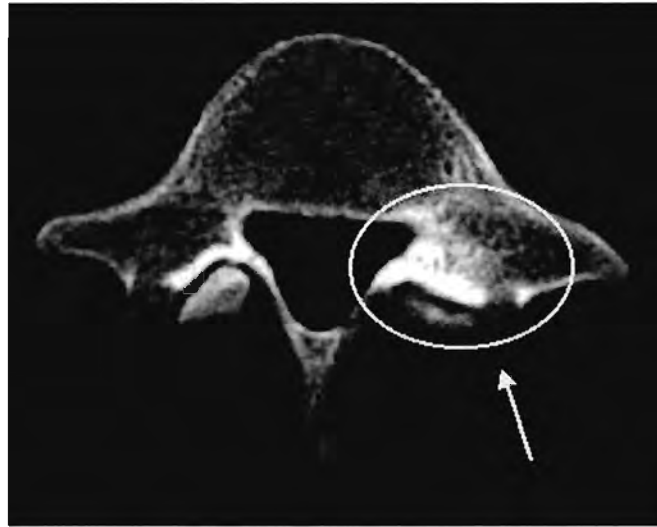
CT scan of a 21-year-old right arm bowler at 3 months showing a thickening of the left pars interarticularis and left pedicle with no stress fracture. The bowler was originally diagnosed with an isotope bone scan as a “left pars interarticularis fracture of 5th lumbar vertebra.”
